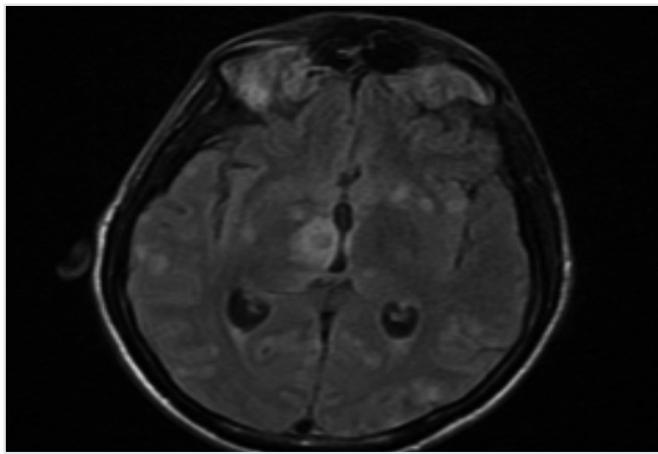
Axial T2-FLAIR images showing hyperintense lesions with edema in the basal ganglia
